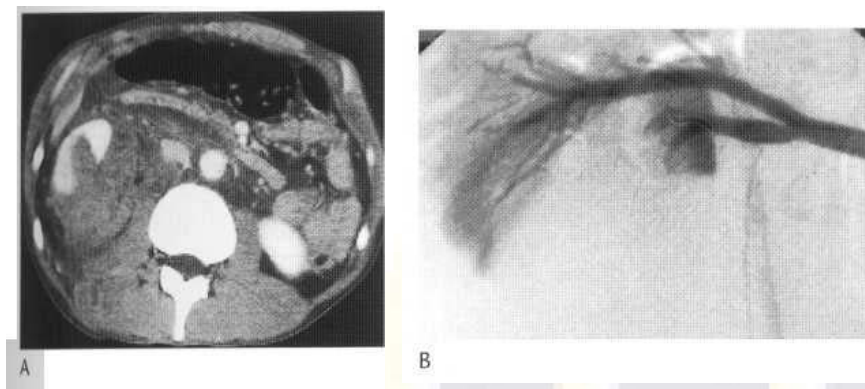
Stab wound resulting in laceration of the lower pole of the right kidney with considerable associated haematoma shown on contrast CT (A). This was successfully treated with selective coil embolisation (B).
